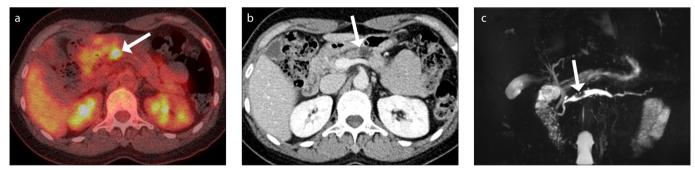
a–c. Case 7, a 50-year-old woman with focal pancreatic ITPN with high-grade dysplasia. PET-CT (a) performed for breast cancer work-up incidentally shows a focal strong ¹⁸F-FDG uptake (*arrow*) in the pancreas body. Axial contrast-enhanced portal phase CT image (b) shows only abrupt cutoff (*arrow*) of the moderately dilated main pancreatic duct in the pancreas body. Two-dimensional MRCP image (c) clearly shows an intraductal tumor (*arrow*) seen as a focal filling defect within the dilated main pancreatic duct.
